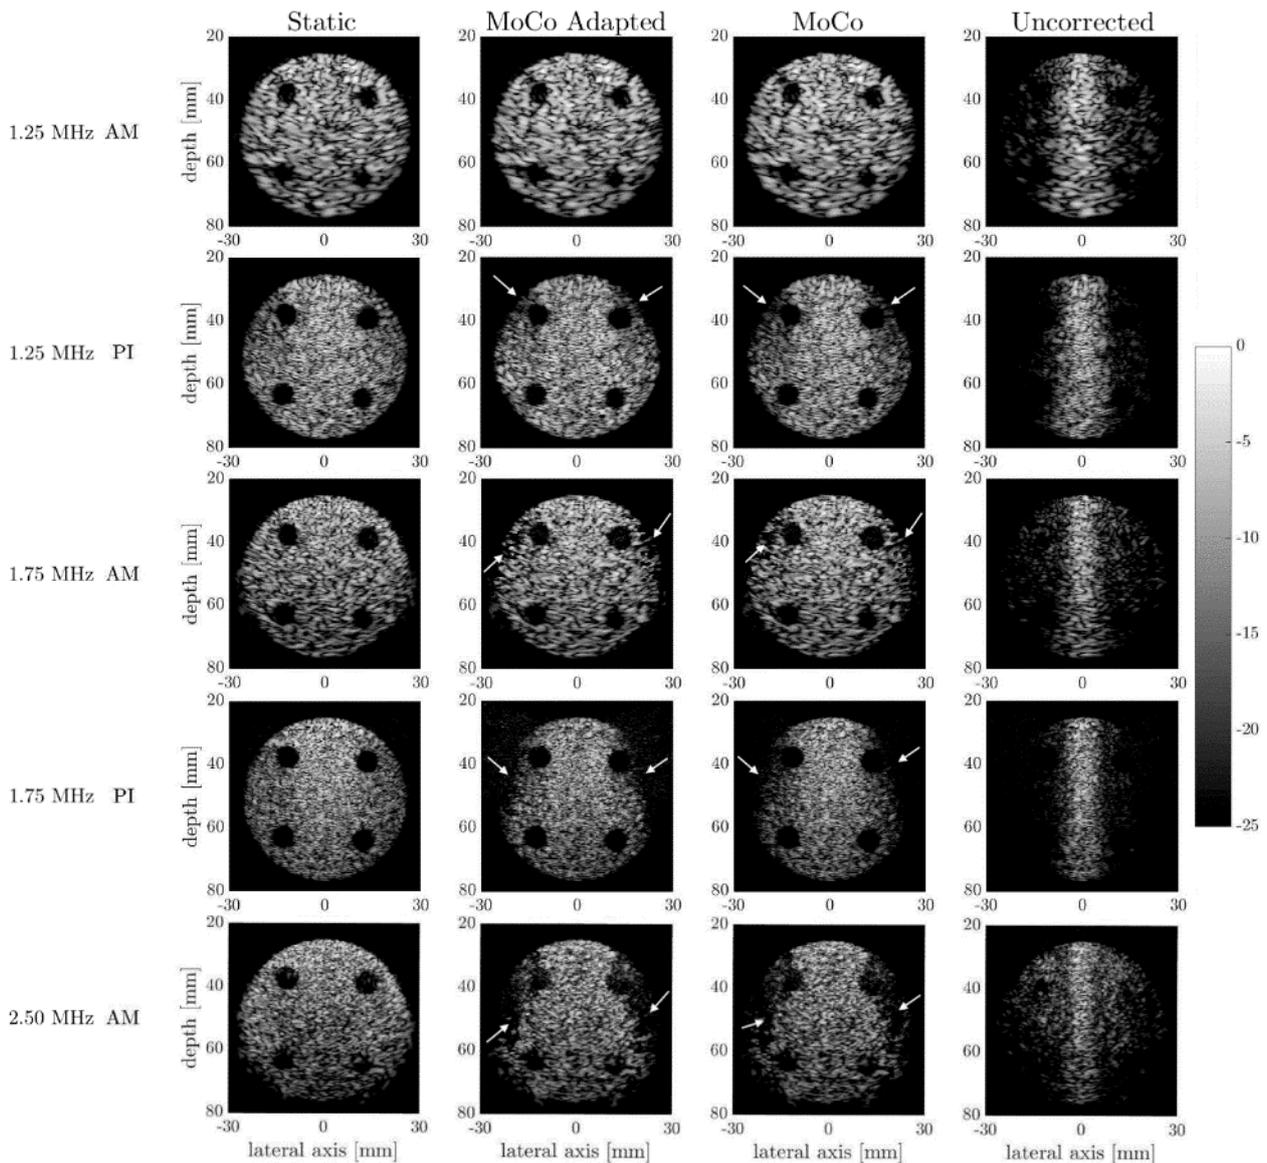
Motion compensation in AM and PI acquisitions at 1.25 MHz (rows 1 and 2), 1.75 MHz (rows 3 and 4) and 2.5 MHz (row 5). Images were depth selected from 20-80 mm and in the lateral direction from -30 to 30 mm for display. Images were normalized according to their own maximum and log-compressed. White arrows point to regions where Doppler aliasing occurred and resulted in loss of intensity. At 1.25 MHz, no aliasing occurs in AM, but a small amount occurs in PI. As the frequency increases, loss of intensity in the edges occurs since the highest velocities occur nearer the edges of the disc.
